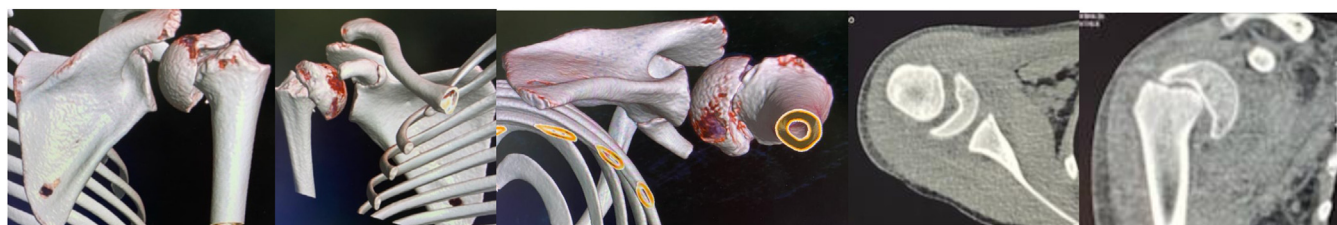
Right shoulder computed tomography scan images showed a displaced fracture of the proximal humerus.
